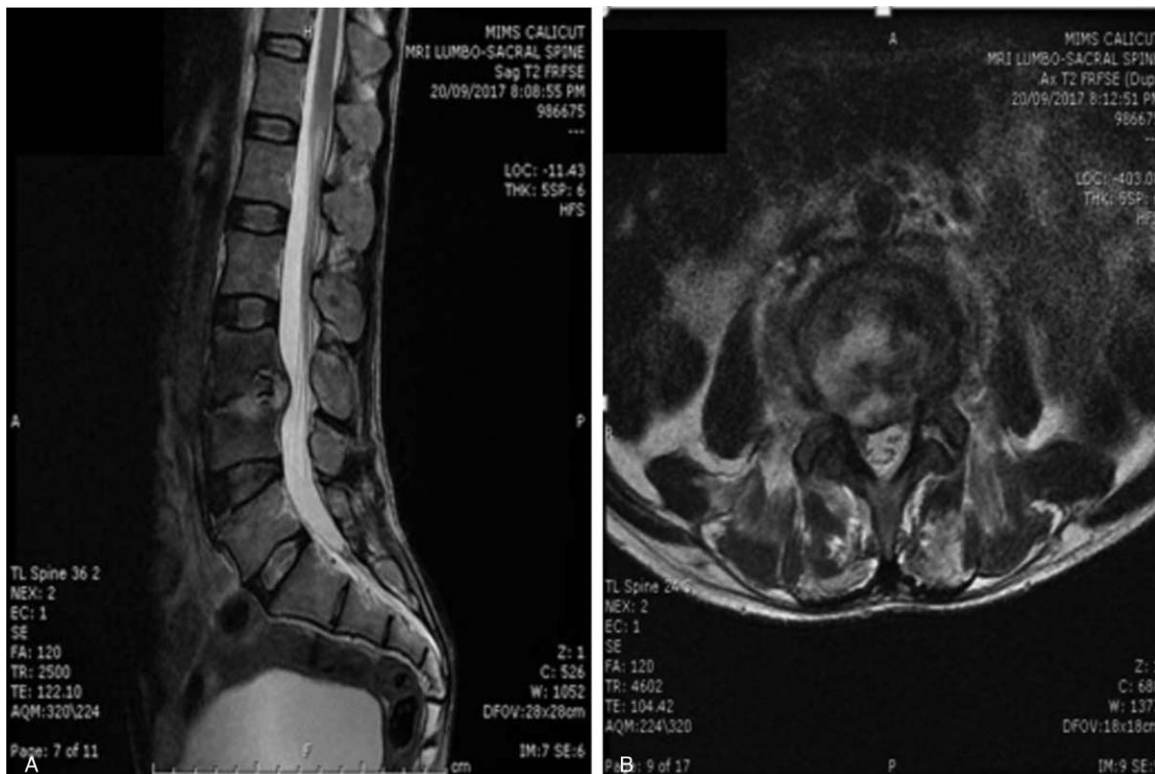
MRI LS spine showing altered signal intensity involving L3-L4 vertebral bodies with hyperintense disc showing contrast enhancement with prevertebral, paravertebral, and epidural soft tissue involvement.
